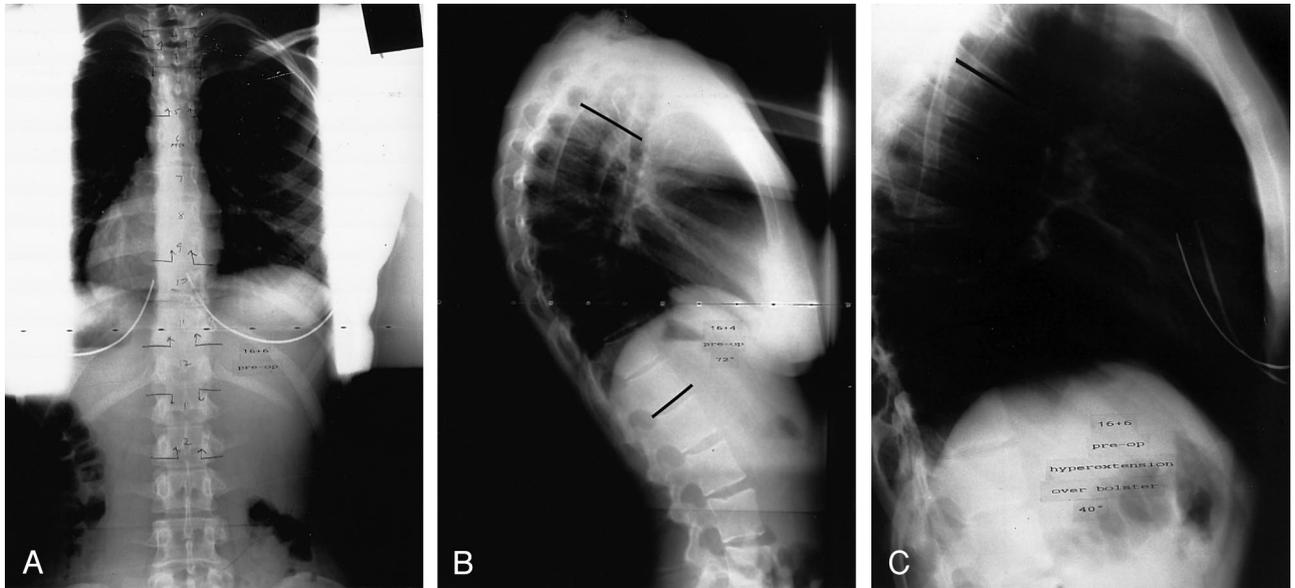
A, Standing PA spinal radiograph – in a 16-year-old girl with Scheuermann's kyphosis and severe back pain. She is skeletally mature. B, Standing lateral preoperative radiograph. The vertebral wedging is typical of Scheuermann's kyphosis. The kyphosis was measured as 72° (modified Cobb method). C, Hyperextension lateral radiograph of the thoracic spine performed over a bolster. The kyphosis reduced to 40°. PA = postero-anterior.
